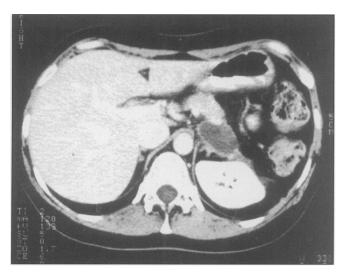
CT scan demonstrating a cystic mass (mucinous cystadenoma) in the tail of the pancreas.
